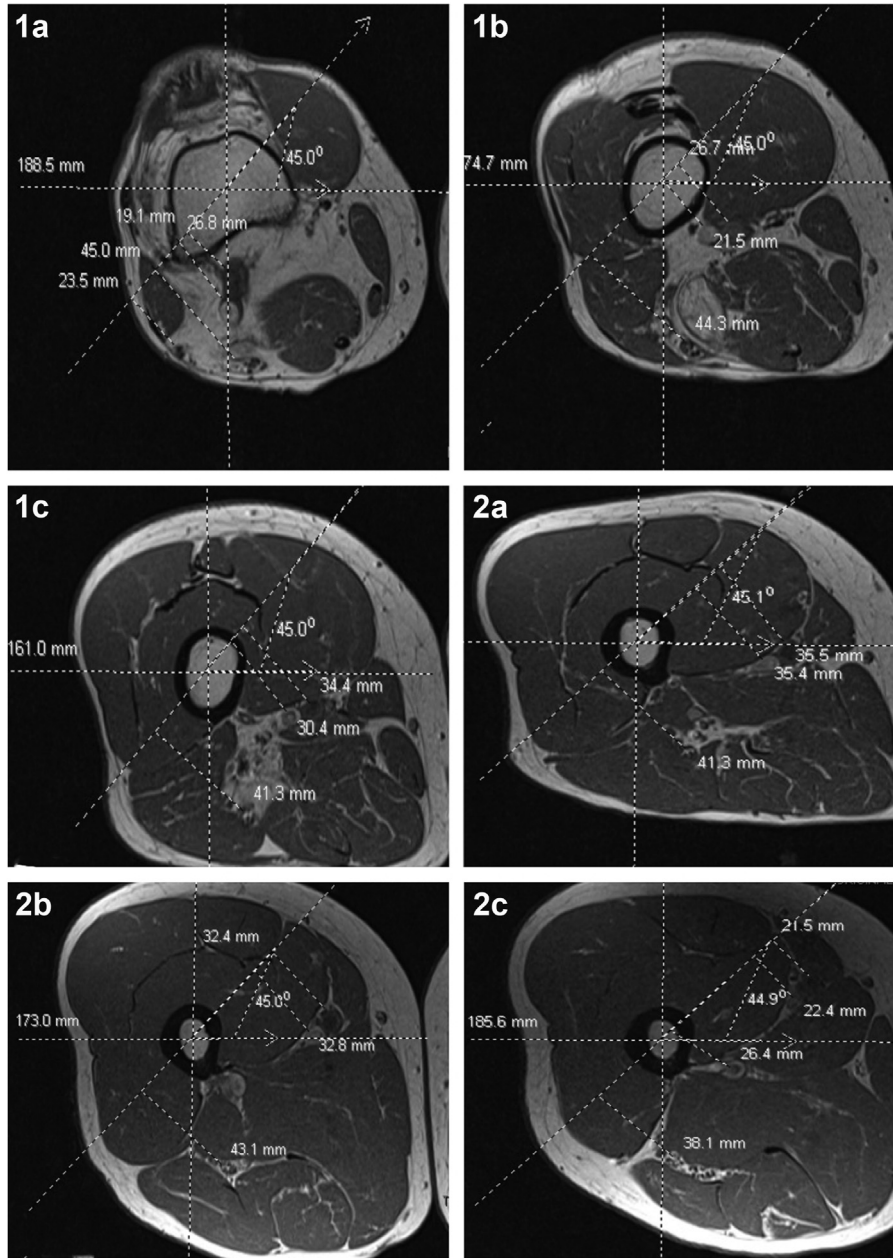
Representative axial MRI of femur at the various zones of study with nearby neurovascular structures identified and distance measured. MRI, magnetic resonance imaging.
